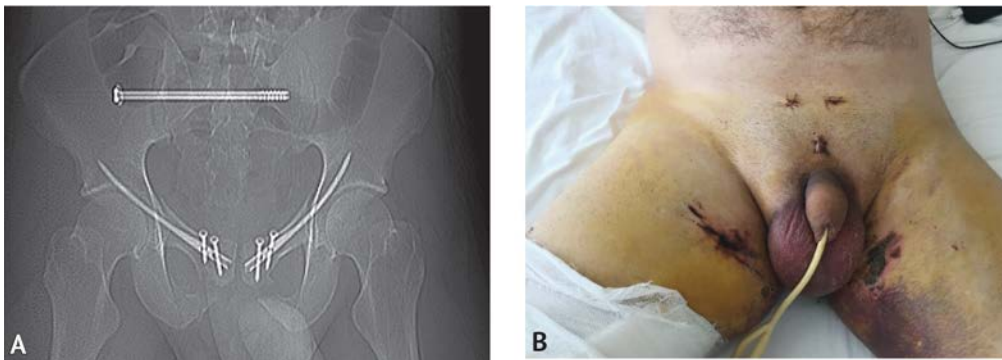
Radiograph after pelvic osteosynthesis with pins and screws (A); local status of the perineal soft tissues after surgery (B)
